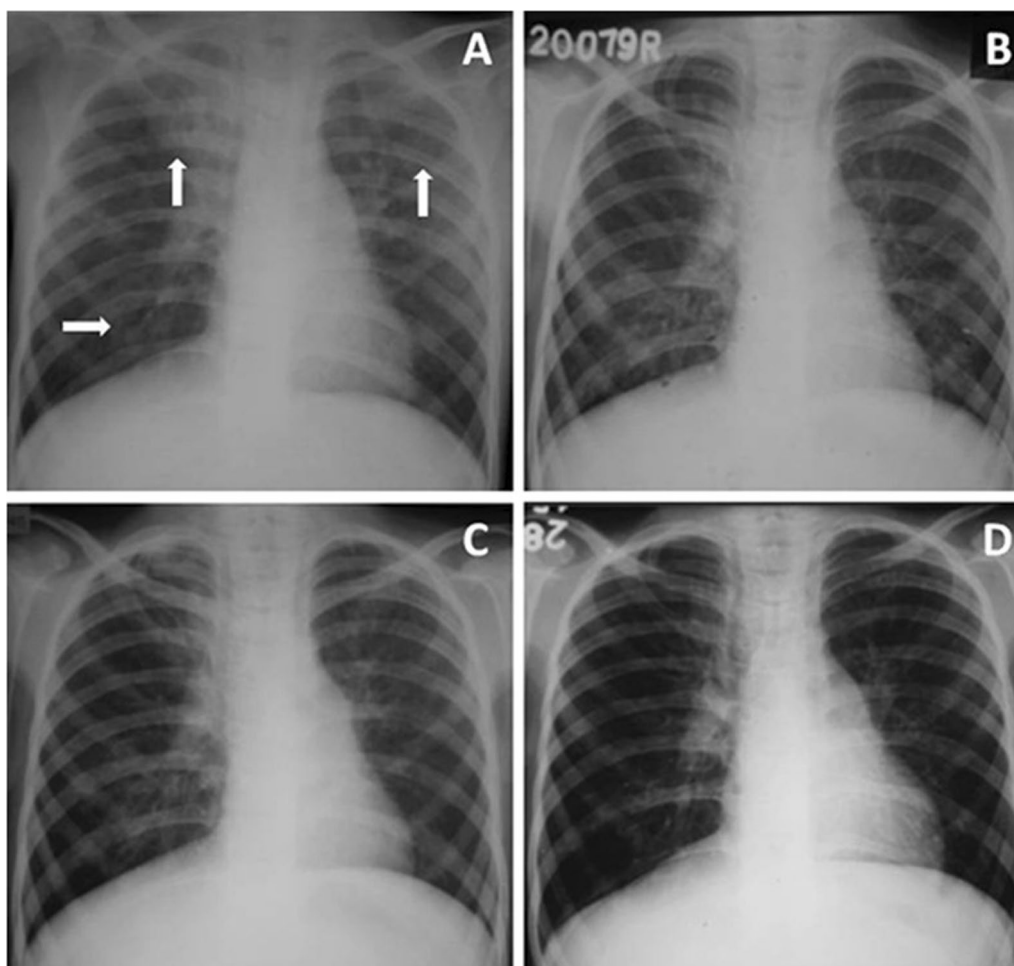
Fungal Infection. A 12-year-old HIV-positive male, presented with fever and cough of 1 week duration. CXR (PA view) reveals inhomogeneous opacity involving bilateral upper zones and right lower zone (arrows, A). Patient showed no improvement after antibacterial treatment for 3 weeks. Sputum sample isolated *Candida* species. CD4 count was 147 cells/cu.mm. Neutrophil count was 35%. Patient was put on antifungal treatment, serial chest radiographs (B,C,D) showed gradual resolution of opacities over a period of 4–5 months
